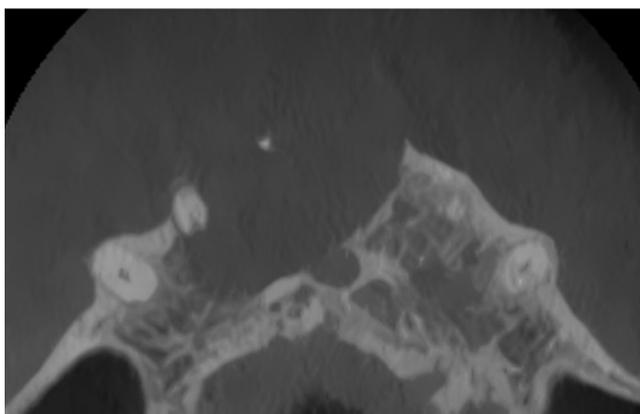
Axial slice of CBCT of Tooth #8 showing unilocular radiolucency extending from Teeth #7 to #9 prior to decompression.
